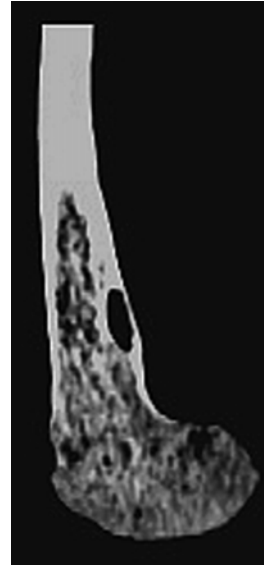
CT scan sagittal view
